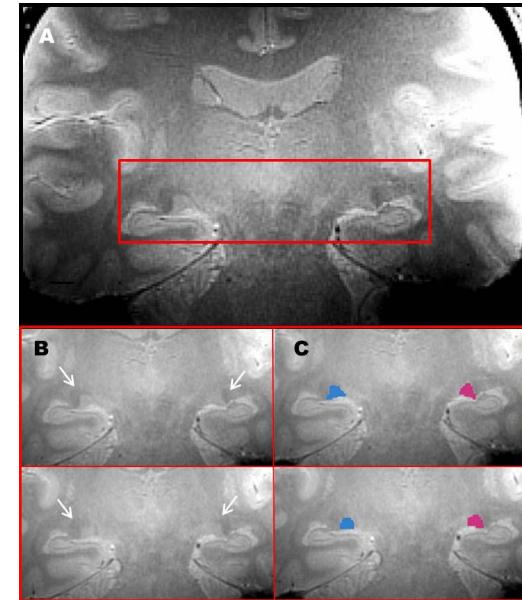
LGN image using 7.0T MRI (top).
